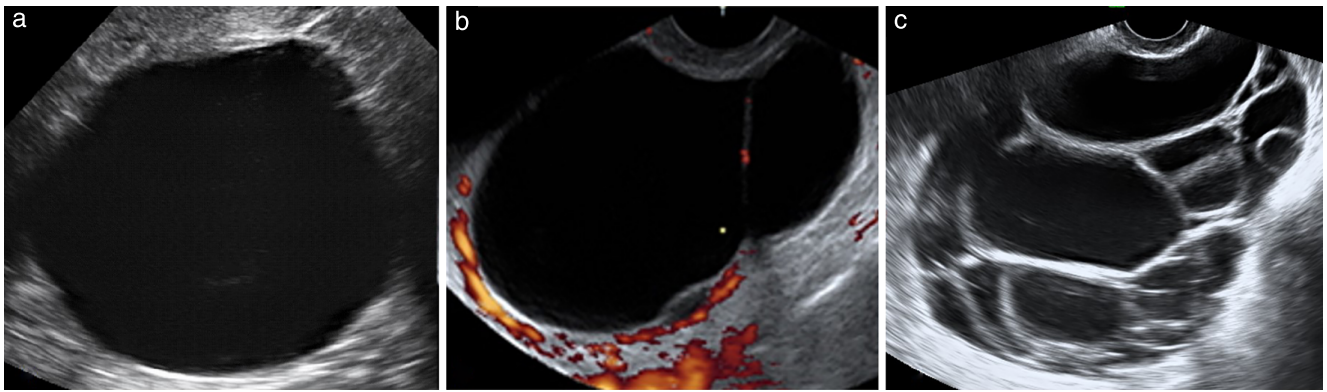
Ultrasound images of serous cystadenofibromas with no solid components. (a) Unilocular serous cystadenofibroma in 53-year-old woman. (b) Bilocular serous cystadenofibroma in 45-year-old woman. (c) Multilocular serous cystadenofibroma in 49-year-old woman.
